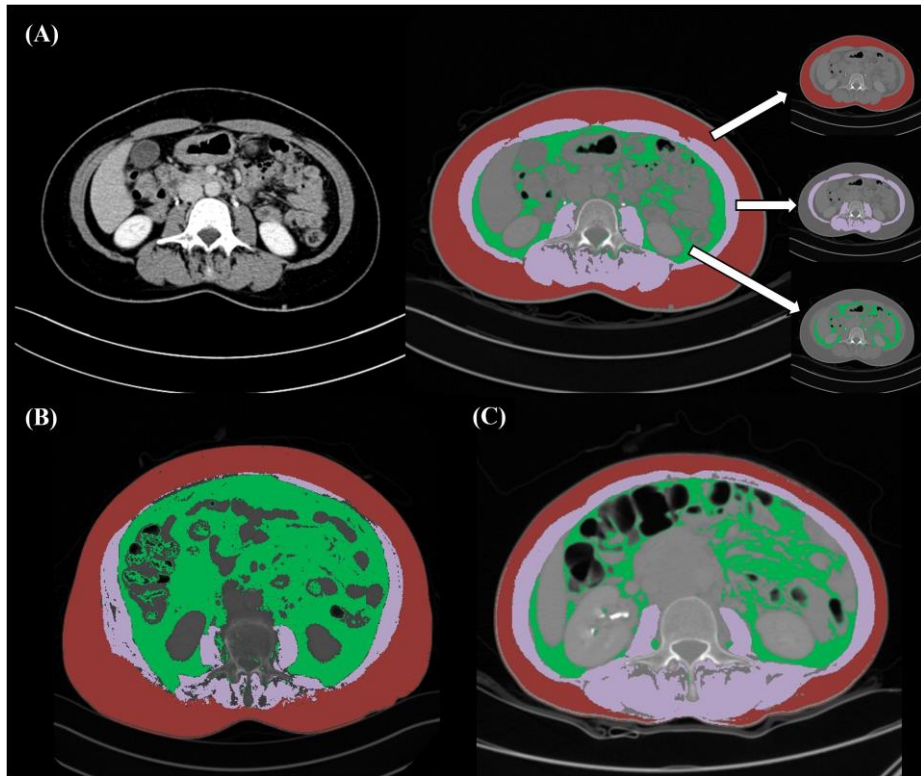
Evaluation of body composition using CT image. Preoperative axial CT image at the level of L3 vertebral body level. (A) A 52-year old woman with newly diagnosed high-grade serous ovarian carcinoma. Total abdominal muscle area (purple), visceral fat area (green), and subcutaneous fat area (red) are segmented by the semi-automatic technique; (B) A 73-year old woman with sarcopenia and high fat-to-muscle ratio (4.6); (C) A 53-year old woman with sarcopenia and low fat-to-muscle ratio (1.5).
